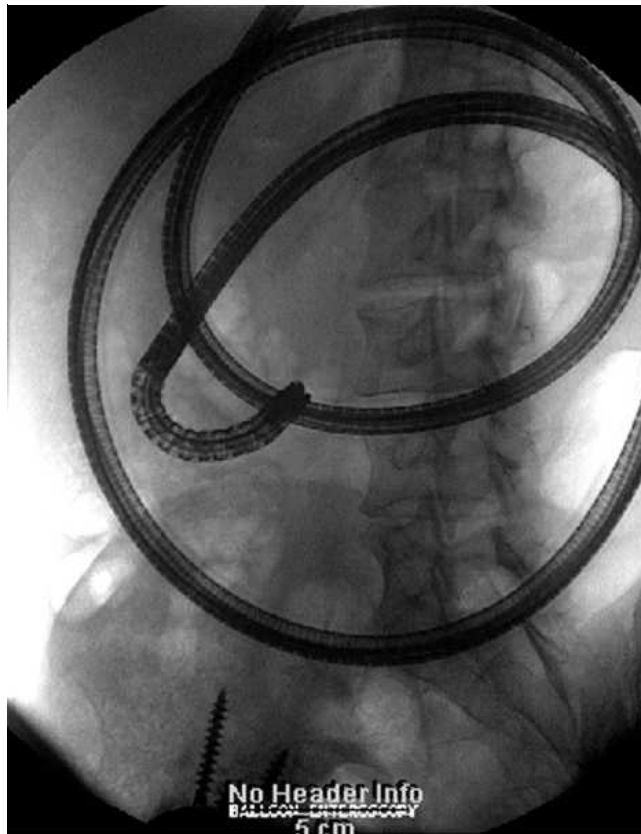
Check radiograph of the endoscope during the enteroscopic procedure.
